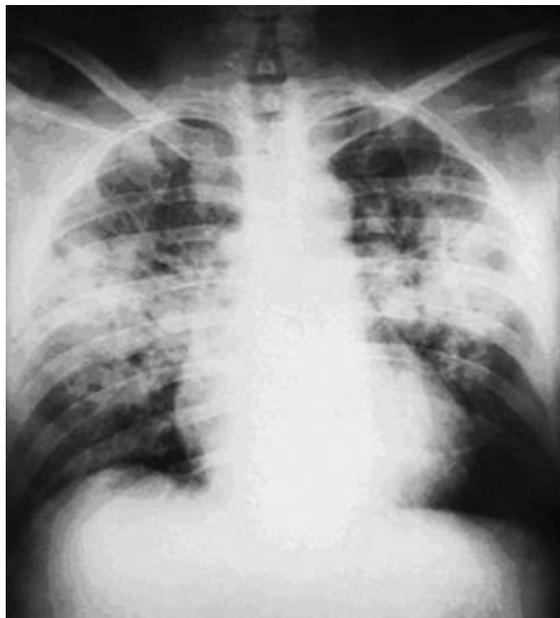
Chest X-Ray showing high altitude pulmonary edema.
